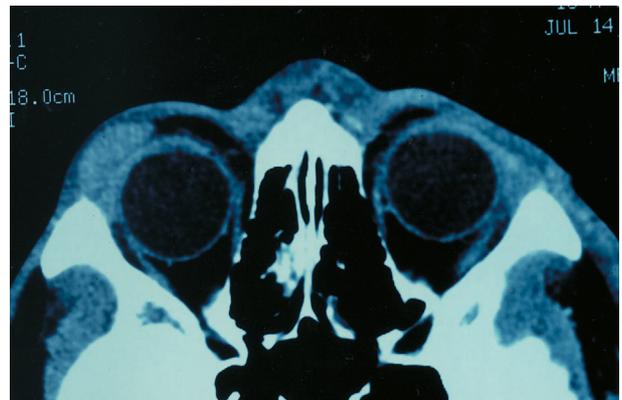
Postoperative orbital CT scan. The scan was performed, and no residual mass was found in his left orbit, but in the right-side orbit, a homogeneous soft-tissue-density mass, which could not be distinguished from the adjacent lacrimal gland, extended deep into the orbit, between the superior and lateral rectus muscles.
